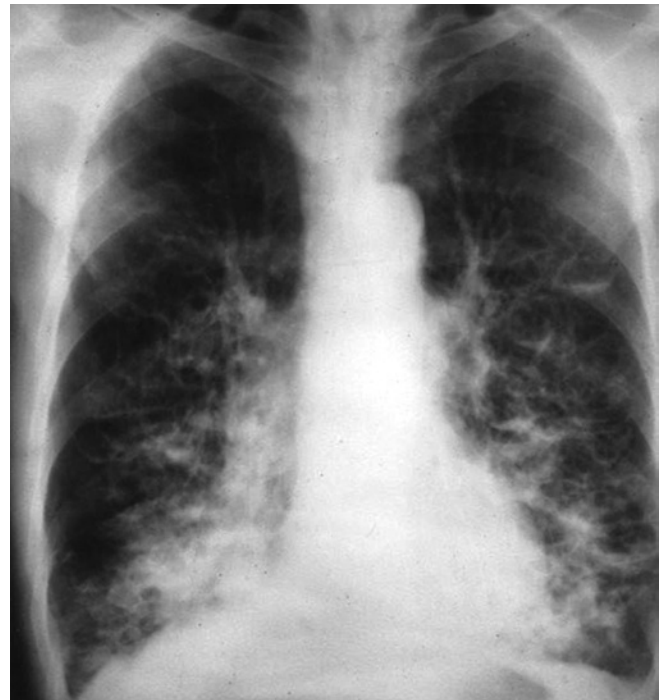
Chest radiograph of a patient with chronic obstructive pulmonary disease showing prominent vascular markings (consistent with chronic bronchitis).
